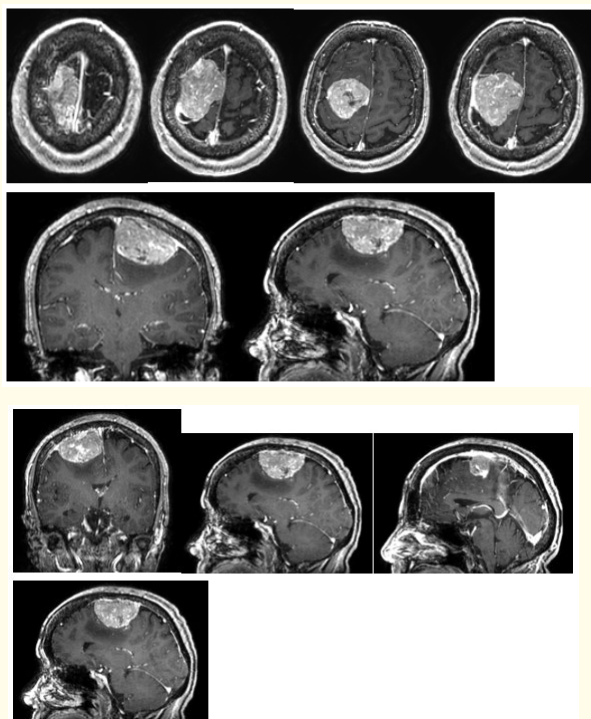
Presurgical brain MRI demonstrating the presence of parasagittal meningiomas.
